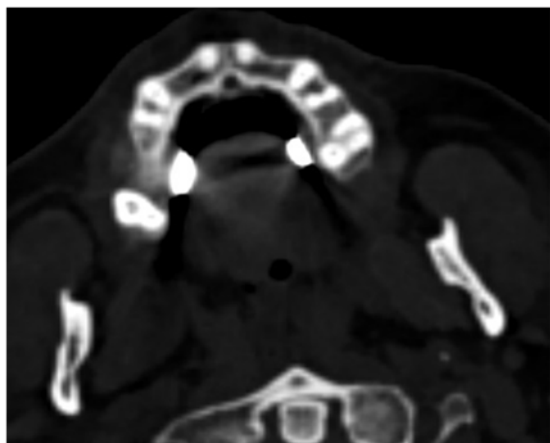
(b) PMCT axial section of lower RCT of teeth 41, 31 and 32. Teeth 36, 38, 42, 46 and 48 are missing. Written clinical dental notes confirm that the RCT of tooth 32 and the removal of tooth 42 were performed after the antemortem CT was taken.
